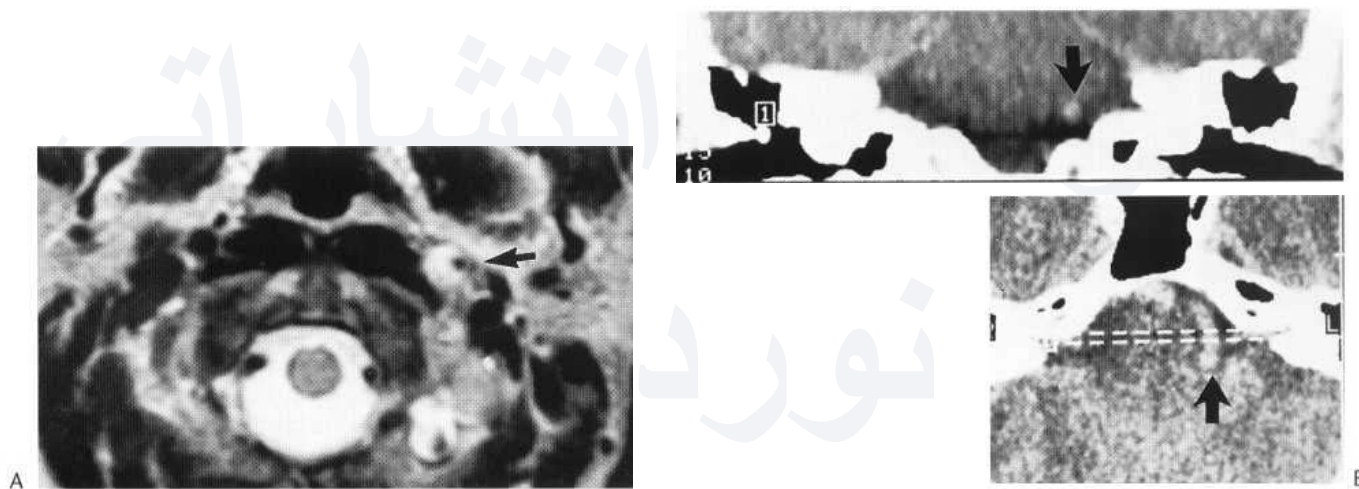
(A) Axial MR section (T_2 -weighted) at base of skull. The right carotid and both vertebrals (lateral to the cord) show no signal due to normal flow. The dilated left internal carotid shows dissection with high signal in the false channel due to low or no flow (arrow). (B) CT with coronal reformat shows kinked vertebral artery arching high into left cerebellopontine angle (arrows) and compressing 7th nerve in a patient with facial tic.
